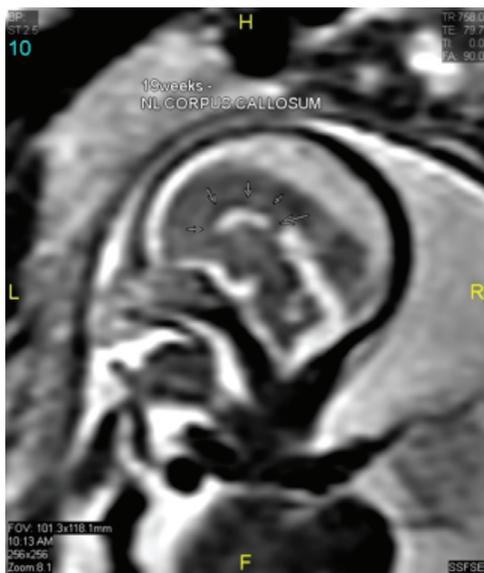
Normal MRI appearance of corpus callosum (MRI image courtesy of D Cohen, MD)
